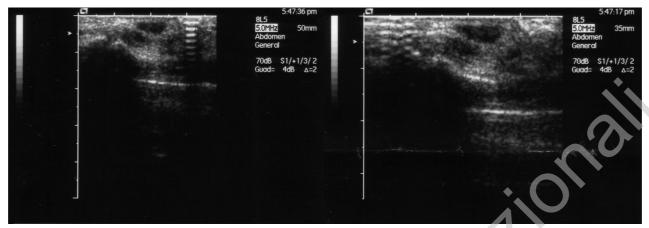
Masson's tumor. Ultrasound showing an oval mass with fluid content, referred to a tendon cyst.
